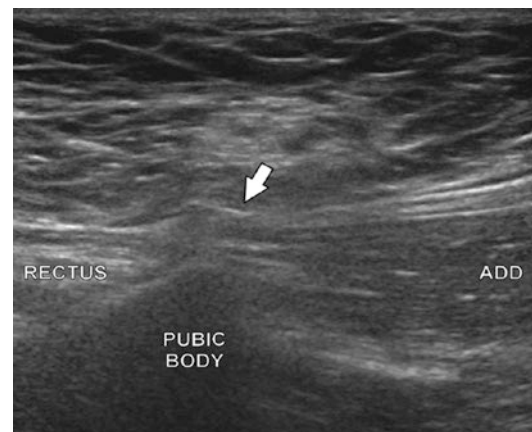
Normal sonographic appearance of the aponeurosis (white arrow). Rectus and adductor longus (ADD) muscles shown
